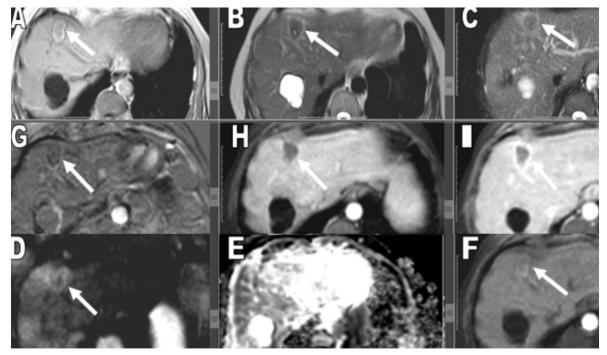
57-year-old male patient with liver cirrhosis underwent radiofrequency ablation of left hepatic lobe segment IV focal lesion. The patient underwent dynamic MRI with diffusion study of 1 & 4 months after the ablation. (A, B & C) axial T1, T2 & SPAIR WI 1 months after the ablation showing the ablated segment IV lesion displaying coagulative necrosis of high T1, low T2 and SPAIR signal (arrows). (D) Diffusion WIs and (E) ADC map at the same level show no diffusion restriction, the ADC value of the entire ablation zone is 1.42 X 10³mm² and of the ADC value of the cirrhotic liver parenchyma is 0.96 X 10³mm² (arrows). (F, G, H & I) Dynamic post contrast axial arterial, arterial subtraction, portal and delayed phase images showed no significant early arterial post contrast enhancement (best appreciated on the dynamic subtraction images) denoting successful ablation with marginally enhancing rim detected on the delayed phase denoting granulation tissue (arrows). Non-enhancing right hepatic lobe cyst is also noted.
